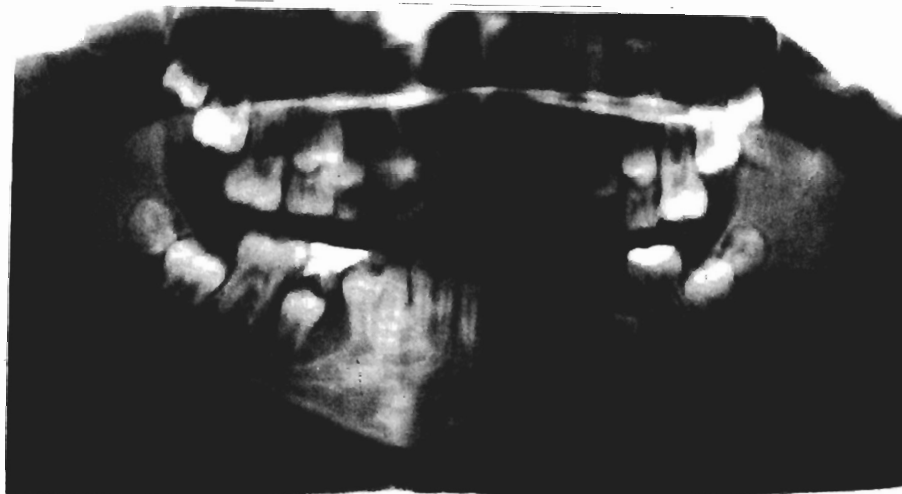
Radiographic view of the lesion in figure 5 one year earlier.
